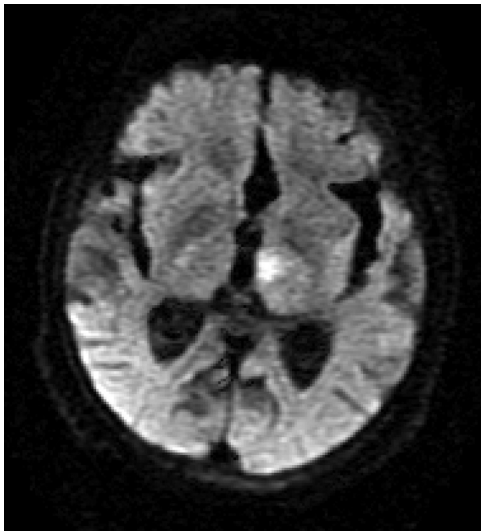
MR images (Diffusion image) revealed small infarction at the left thalamus and the posteromedial of left thalamus.
